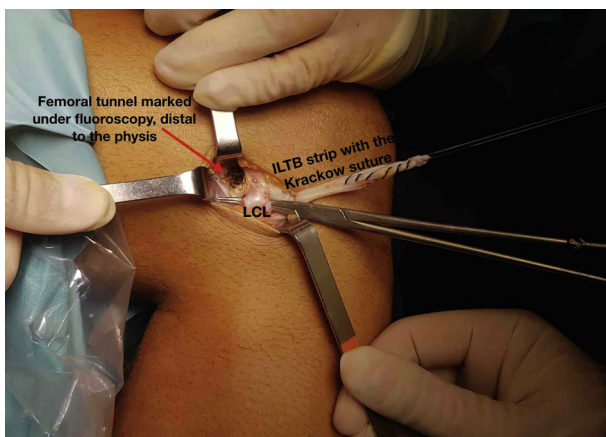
Identification of femoral entry point. Guided by the x-ray intensifier, the femoral guide entry point is confirmed distal to the femoral physeal growth plate.
